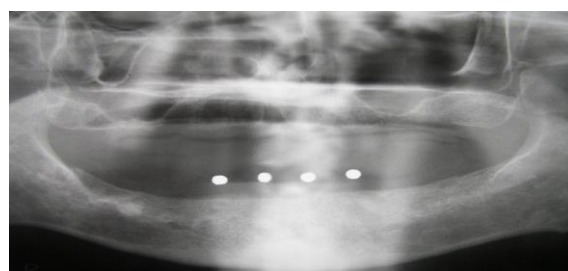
Orthopantomograph with visible lead markers
